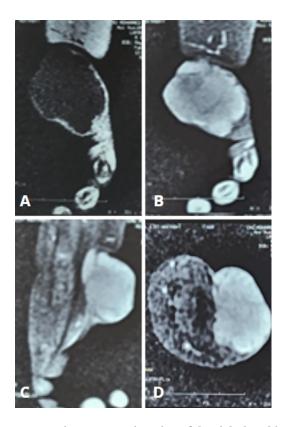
Magnetic resonance imaging of the right hand in non-fat-saturated T1-weighted coronal section without contrast injection (A), fat-saturated T1-weighted sequence in coronal section with contrast injection (B), fat-saturated T2-weighted sequence in sagittal section (C), and fat-saturated T2-weighted sequence in axial section (D) showing a well-defined, lobulated soft tissue mass with regular contours, located in the subcutaneous tissues of the thenar and hypothenar compartments of the right hand measuring 42 x 35 mm. The mass demonstrates exophytic growth with isointense T1 signal, hyperintense T2 signal, and intense homogeneous enhancement after contrast injection.
